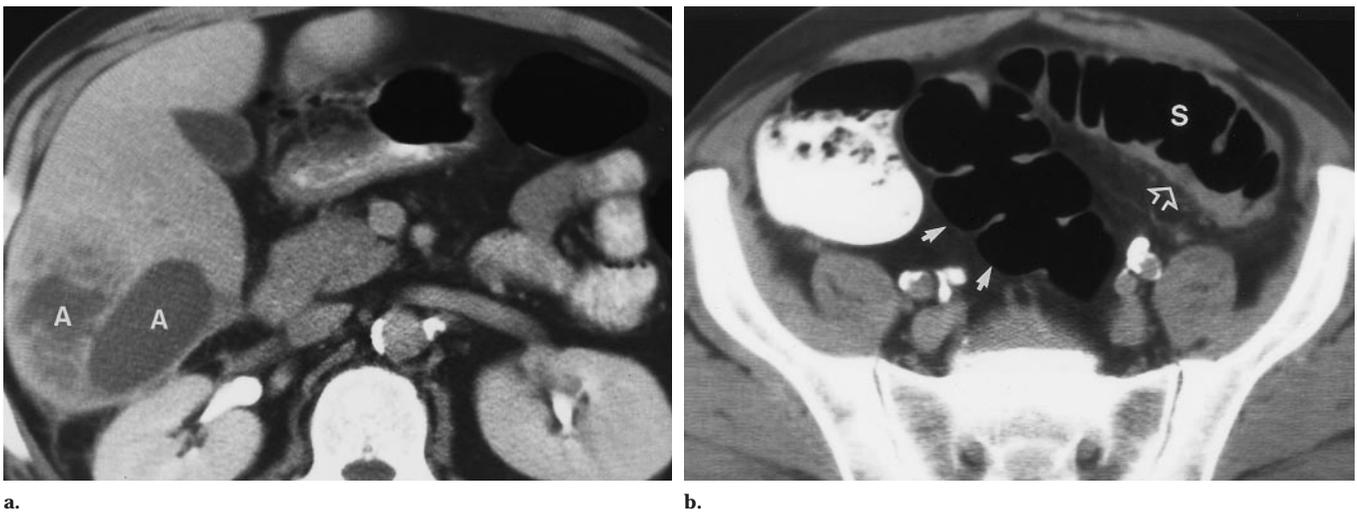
Ischemic sigmoiditis in a 57-year-old man who presented with fever and had an elevated WBC count and guaiac-positive stools. (a) Contrast-enhanced CT scan reveals a multilocular abscess (A) in the right lobe of the liver. (b) CT scan shows that proximal sigmoid colon (S) has a circumferential thickened wall (open arrow), which contrasts with the normal-appearing distal sigmoid colon (solid arrows). Sigmoidoscopy with biopsy showed erythematous mucosa, moderate inflammation, and marked hemosiderin deposits consistent with ischemic colitis.
